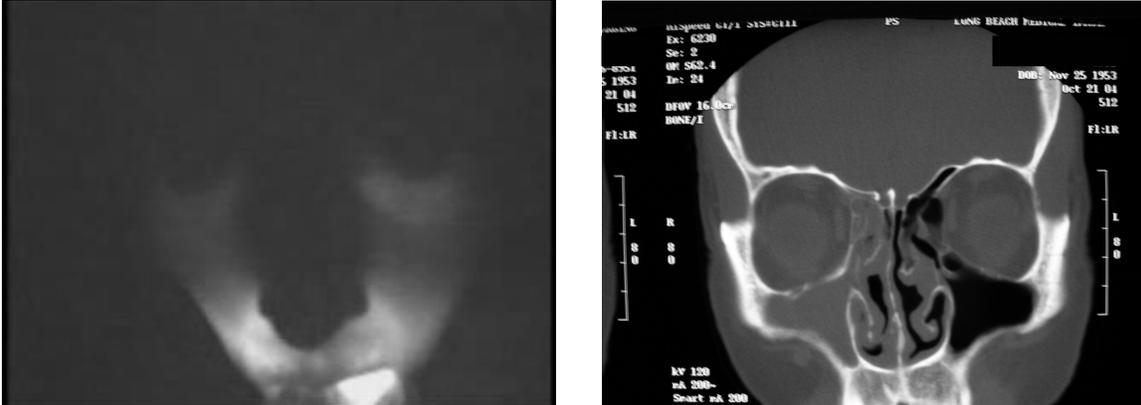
NIR transillumination pattern (left) of 51 year old Caucasian male with a diagnosis of unilateral maxillary sinusitis with corresponding CT scan (right) revealing total opacification of right maxillary sinus. Though subtle, note relatively dim transillumination pattern or right mid-face regions as compared to left, with particularly diminished light penetration through right infraorbital rim.
